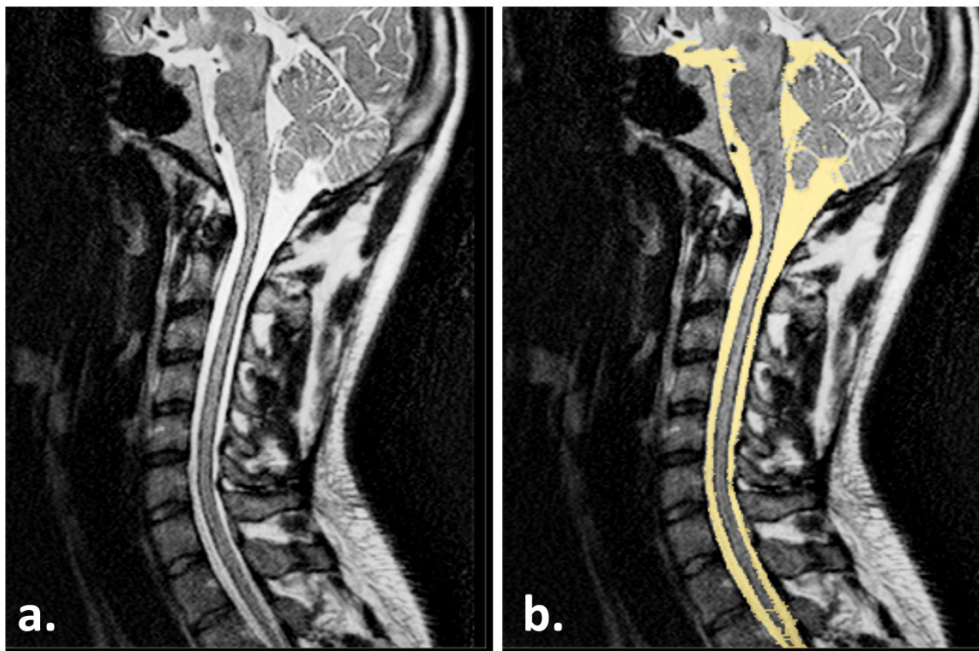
a) T2 weighted MRI image of the cervical spine for the healthy volunteer. b) Example of manual segmentation of the SSS from the T2-weighted MRI for one operator.
